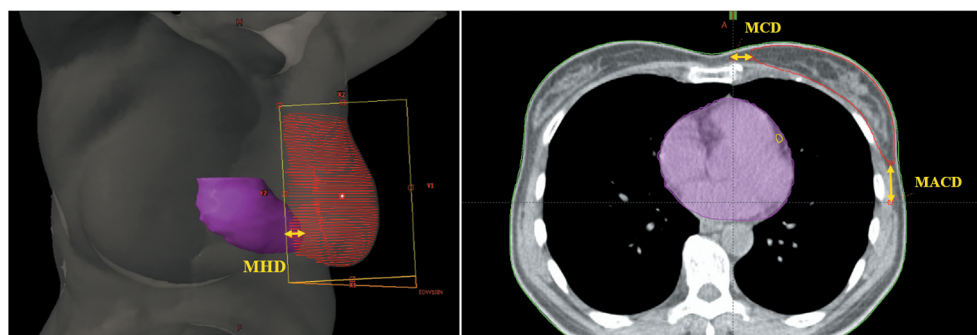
Representations of maximum heart distance (MHD), marginosternal CTV distance (MCD) and the midaxillary CTV distance (MACD). (Left) Beam's eye view of the medial tangential field for a typical patient, in which the MHD, defined as the maximum distance between the anterior cardiac contour (magenta) and the posterior tangential field edges, is indicated. This distance was calculated for both free breathing (FB) and deep inspiration breath hold (DIBH) plans. (Right) Axial projection of the CT scan in FB in which the distance between the medial limit of the CTV contour (red) and the MCD and the distance between the lateral limit of the CTV and the MACD are shown.
